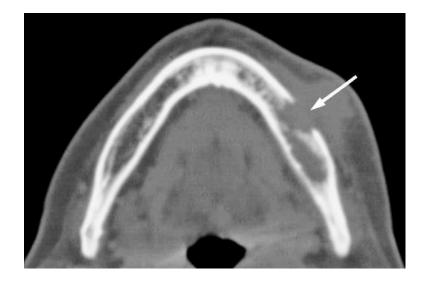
Axial CT image of a suppurative osteomyelitis with cortical bone perforation (arrow).
